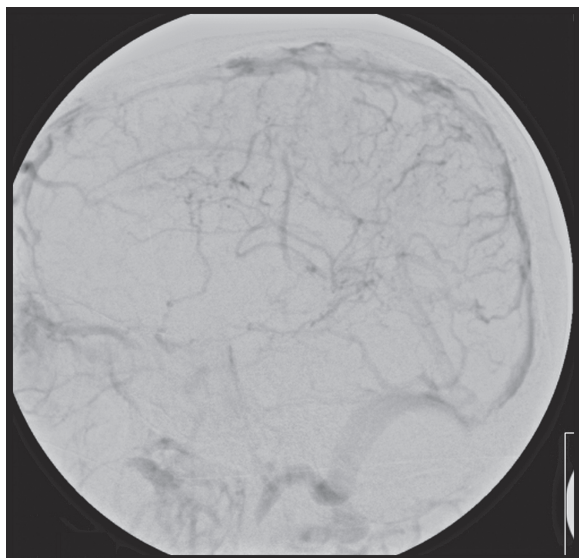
Cerebral angiogram. Venous phase of cerebral angiogram showing improved flow through dural venous sinuses following ultrasound thrombolysis.
